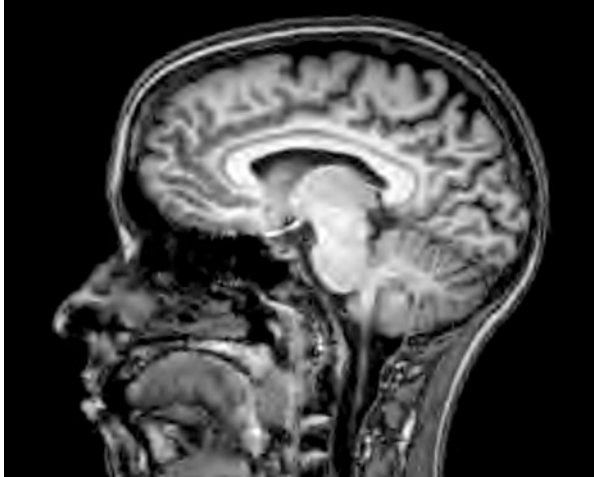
Encephalic magnetic resonance imaging (MRI)
